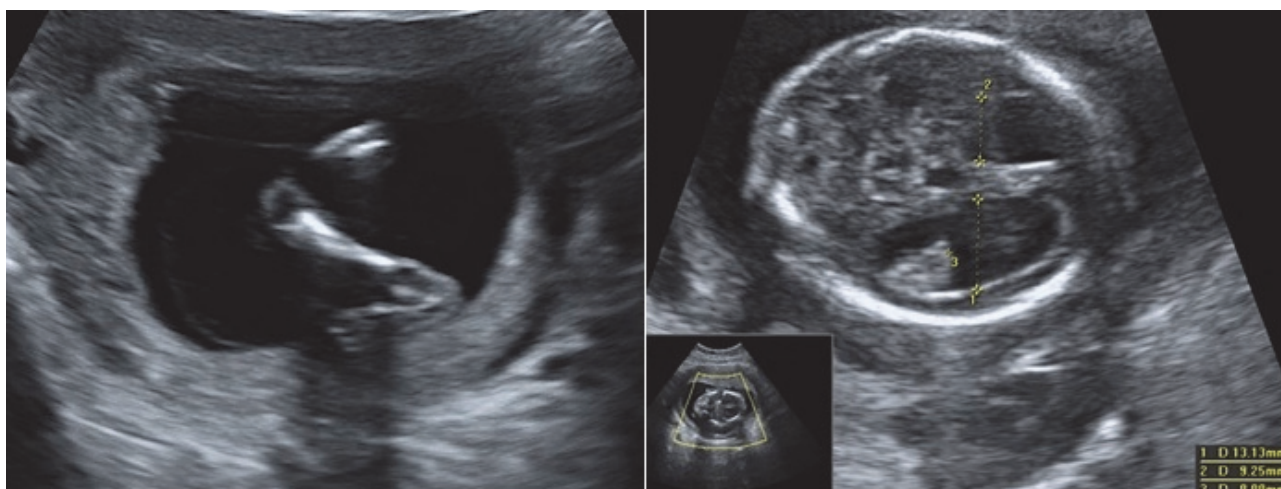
Ultrasound image showing: A) clubfoot, and B) ventriculomegaly.
